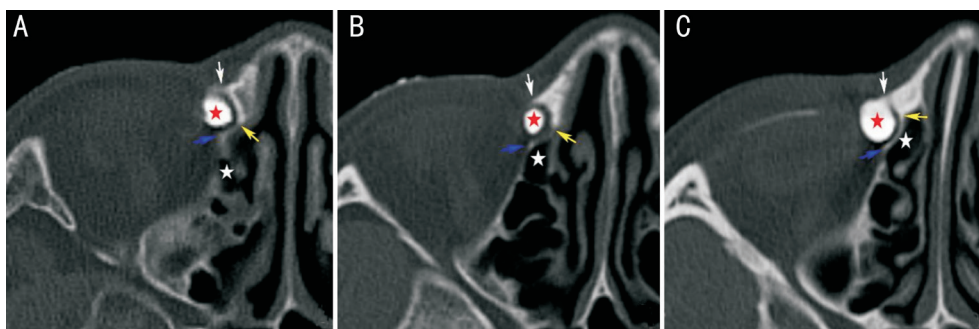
Categories of ethmoid sinuses determined by axial sections of CT-DCG showing the relationship between the lacrimal fossa (red star) and the anterior ethmoid air cells (white star) A: Absence of sinuses anterior to the posterior lacrimal crest (blue arrow); B: Sinuses present anterior to the posterior lacrimal crest (blue arrow), but remain behind the suture of the lacrimal bone (yellow arrow); C: Sinuses found anterior to the lacrimal bone suture (yellow arrow).
